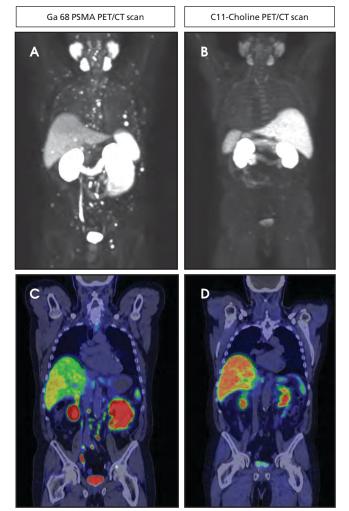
Axial view showing innumerable lesions on Ga68 PSMA PET/CT scan with minimal- to low-level disease on the comparison C-11 choline PET/CT scan.
